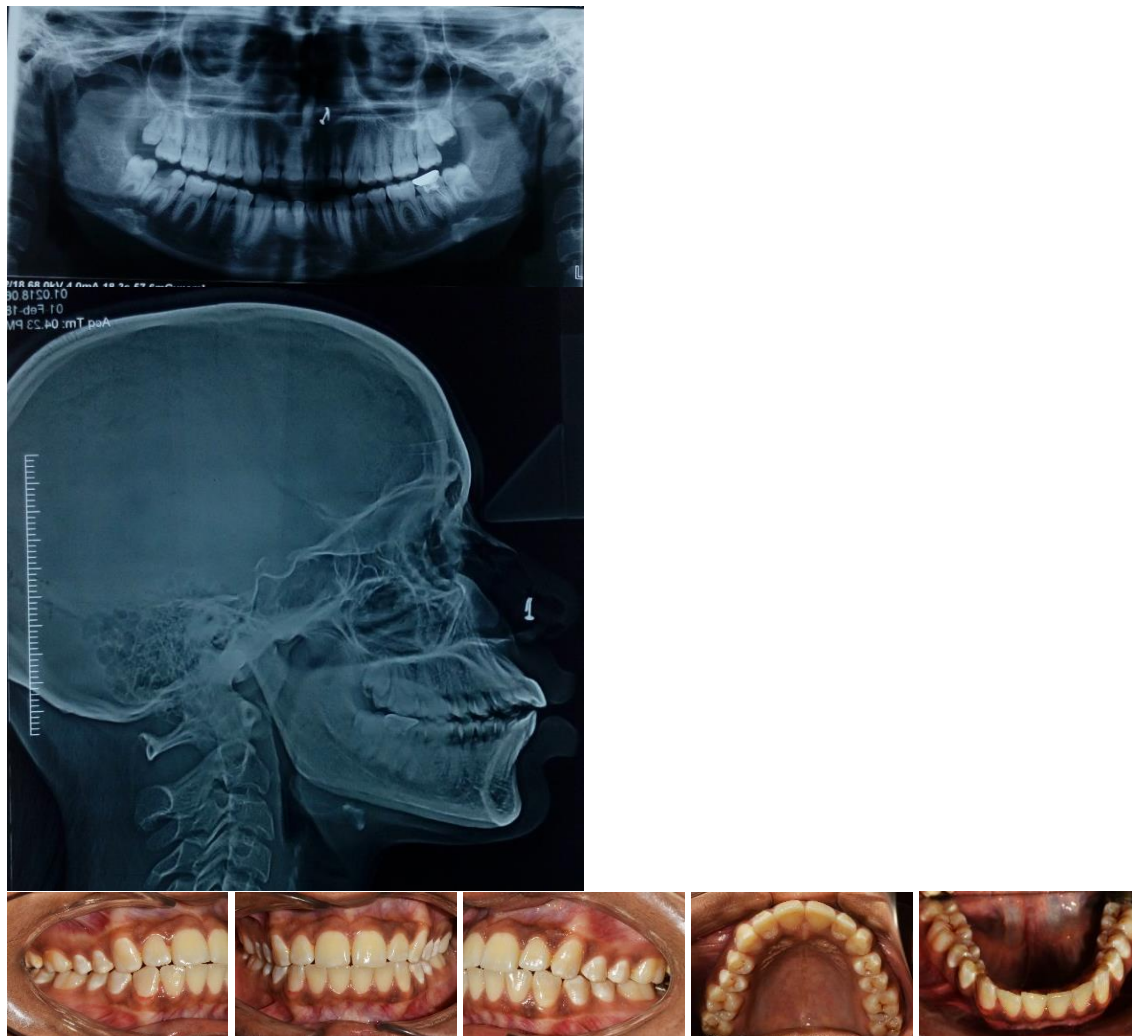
Pre-treatment intraoral images displaying bimaxillary protrusion, along with the lateral cephalogram and orthopantomogram (OPG).
